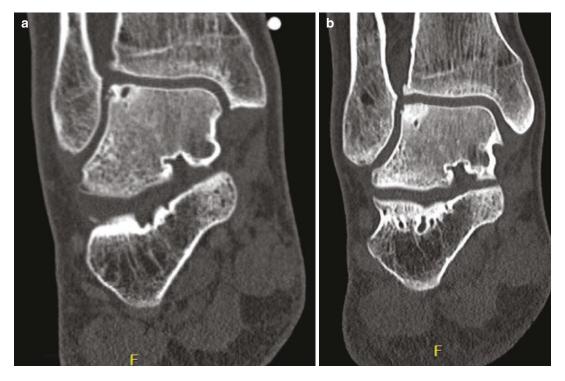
Preoperative and 1-year postoperative computed tomography scans of a patient treated with an arthroscopic lift, drill, fill, and fix (LDFF) procedure. (a) Preoperative coronal CT scan. (b) 1-year postoperative coronal CT scan
